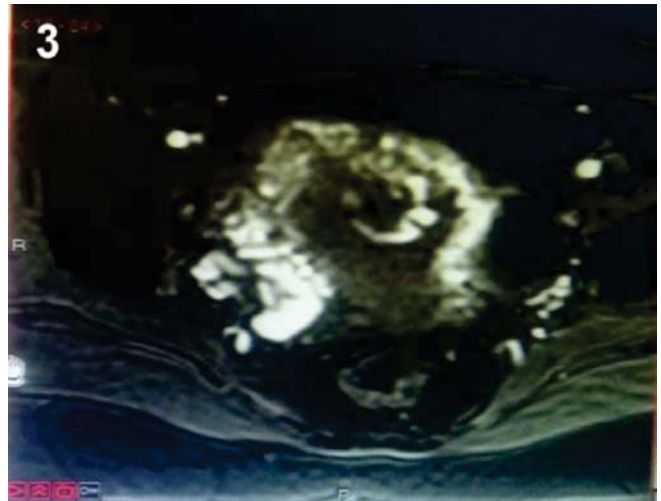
T2 MRI showing dynamic contrast enhancement consistent with vascular malformations.
